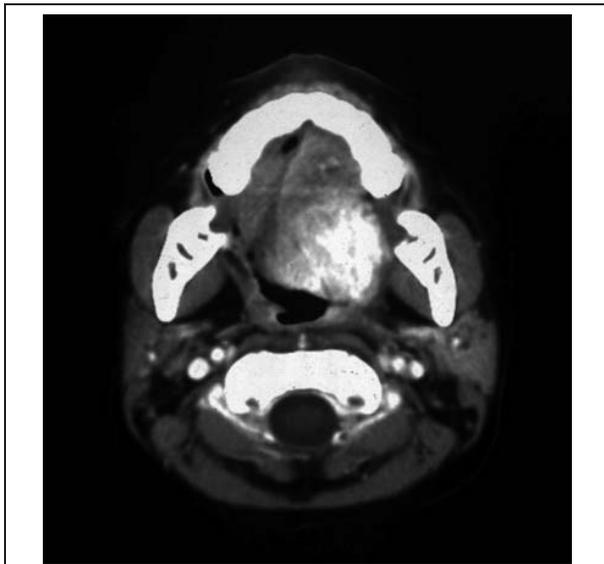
The recurrent tumor on CT scans before seed implantation.
